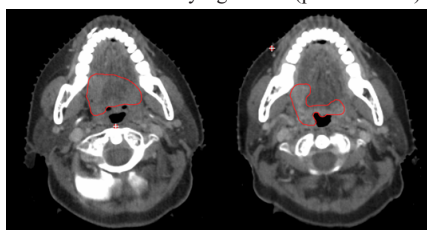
Shows contoured GTV (in red) in pre-treatment CT (left image) and interval CT scan at 16 fractions (right image).
